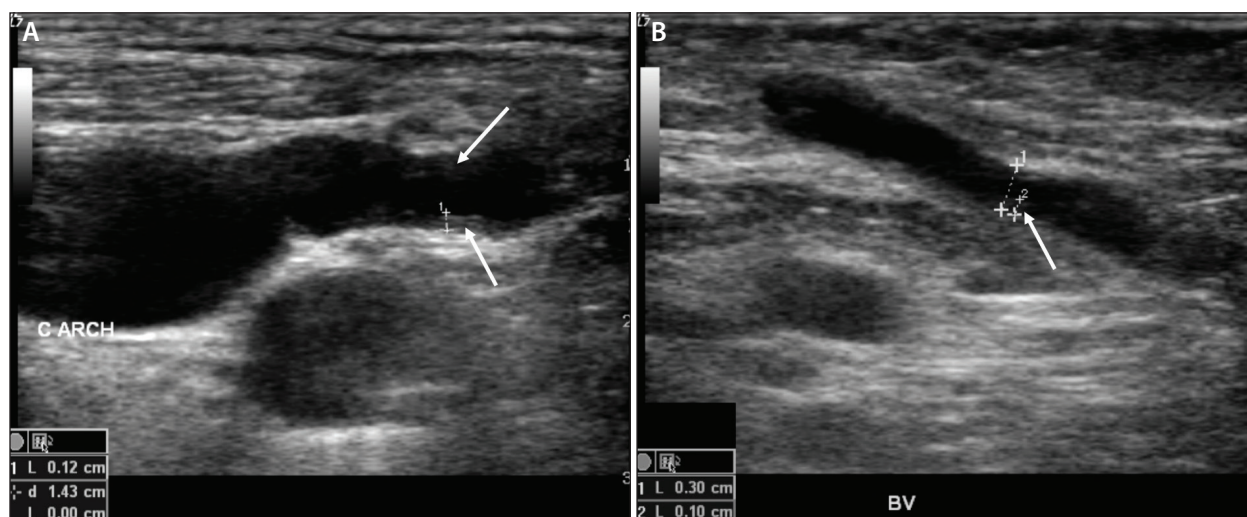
B-mode ultrasound image of a brachiocephalic fistula demonstrating a cephalic arch stenosis in which there is less intimal hyperplasia (white arrows) as compared with Figure 1 (A). There is an outer-to-outer diameter reduction in the vein, which may reflect a more fibrotic stenosis. B-mode ultrasound image of a brachiocephalic venous transposition demonstrating a stenosis at the surgical "swing point" (B). There is intimal hyperplasia (white arrow), but there is a more significant diameter reduction of the vein, which measures 3 mm in diameter.
